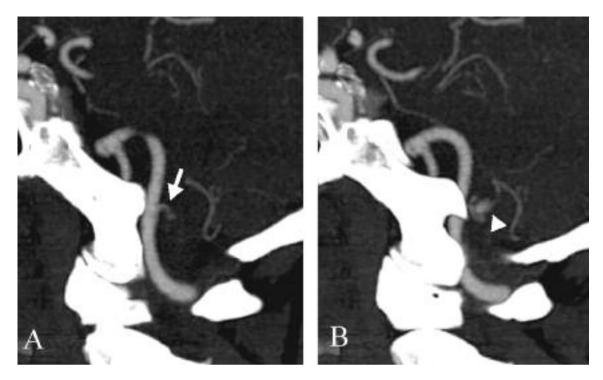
(A) CT angiography three months later reveals proximal left PICA recanalization (arrow). (B) Aneurysm remains unchanged (arrowhead).
